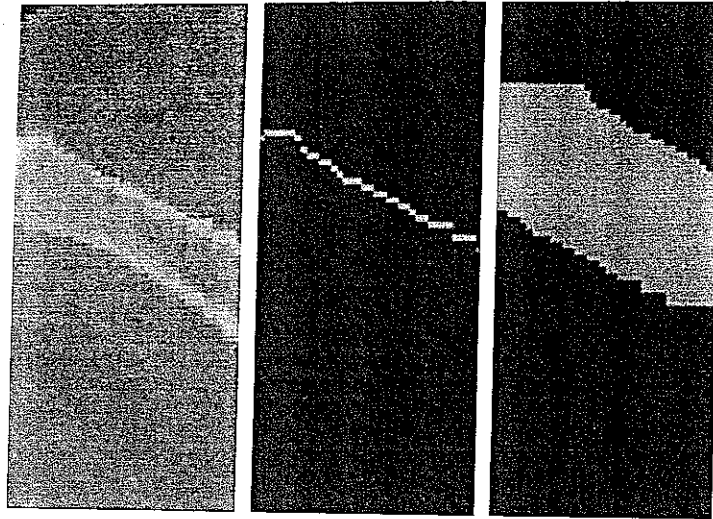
Left: CT cross-section corresponding to a given US image. Center: Bone surface from CT image. Right: Initial estimate of bone surface region
